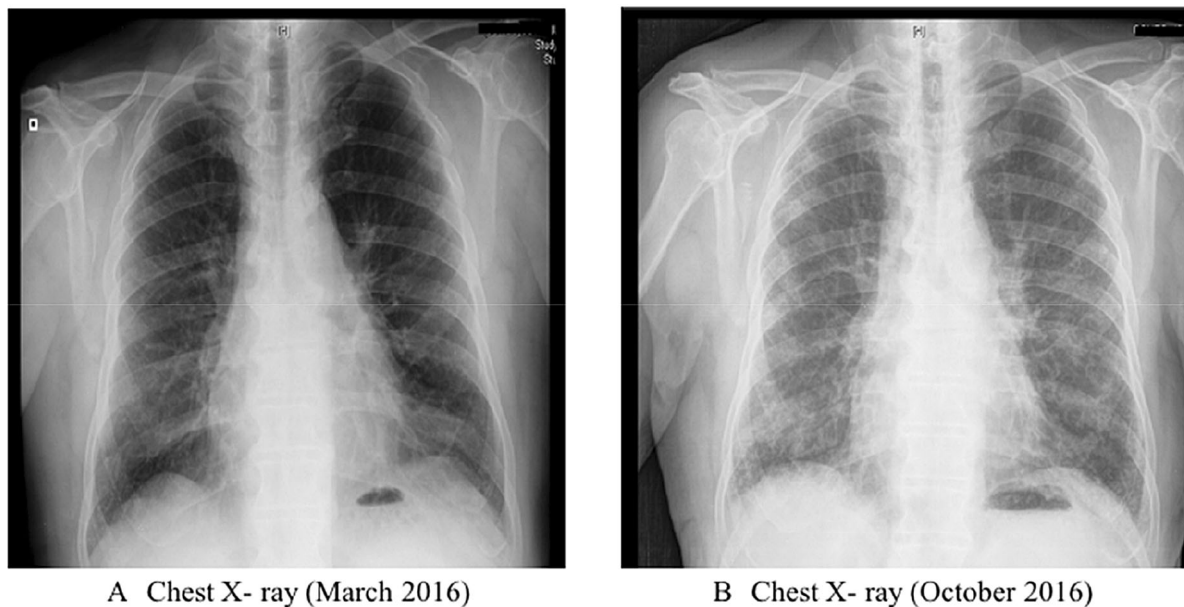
Chest X-ray before (a) and after (b) oxaliplatin treatment
